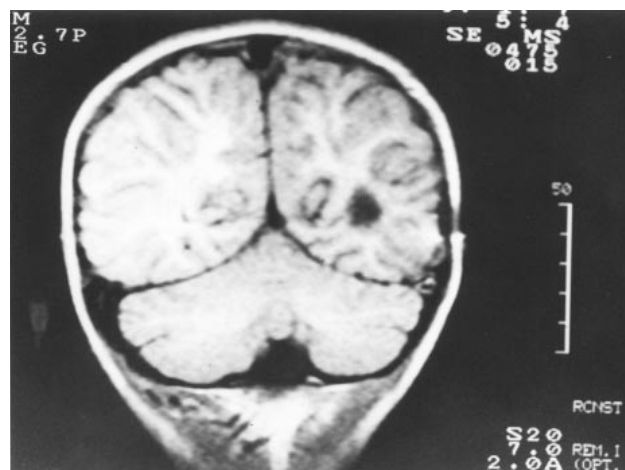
T1-weighted coronary cranial MRI taken 1 year after the operation. Cerebral tissue filled the cyst cavity and brain appearance is normal.
